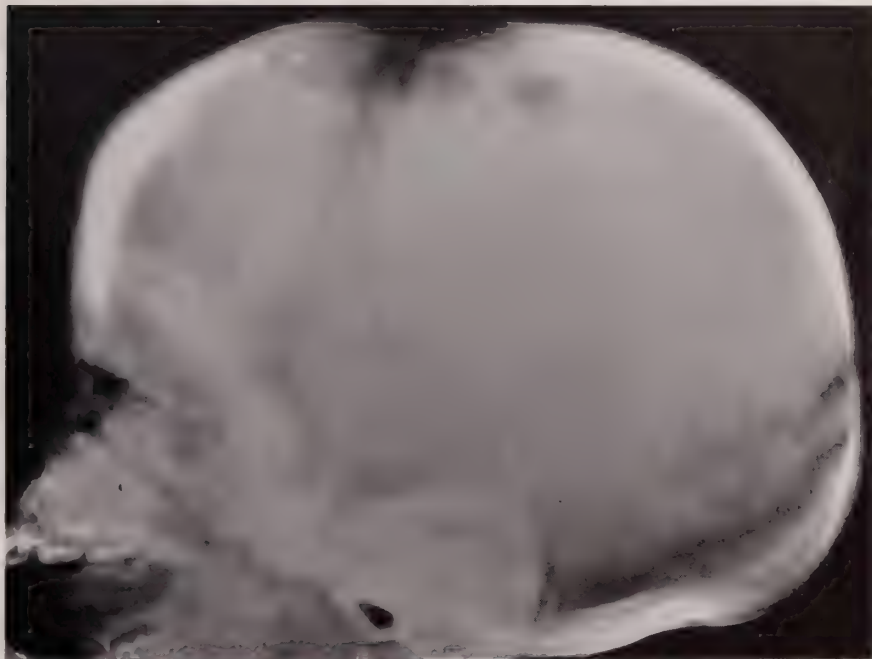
Iron Deficiency Anemia. Skull of same patient taken at 3 months of age. Early changes are already apparent in the frontal bone. (Moseley, J. E.: *Am. J. Roentgenol. & Rad. Therapy*, 8: 649, 1961.)
